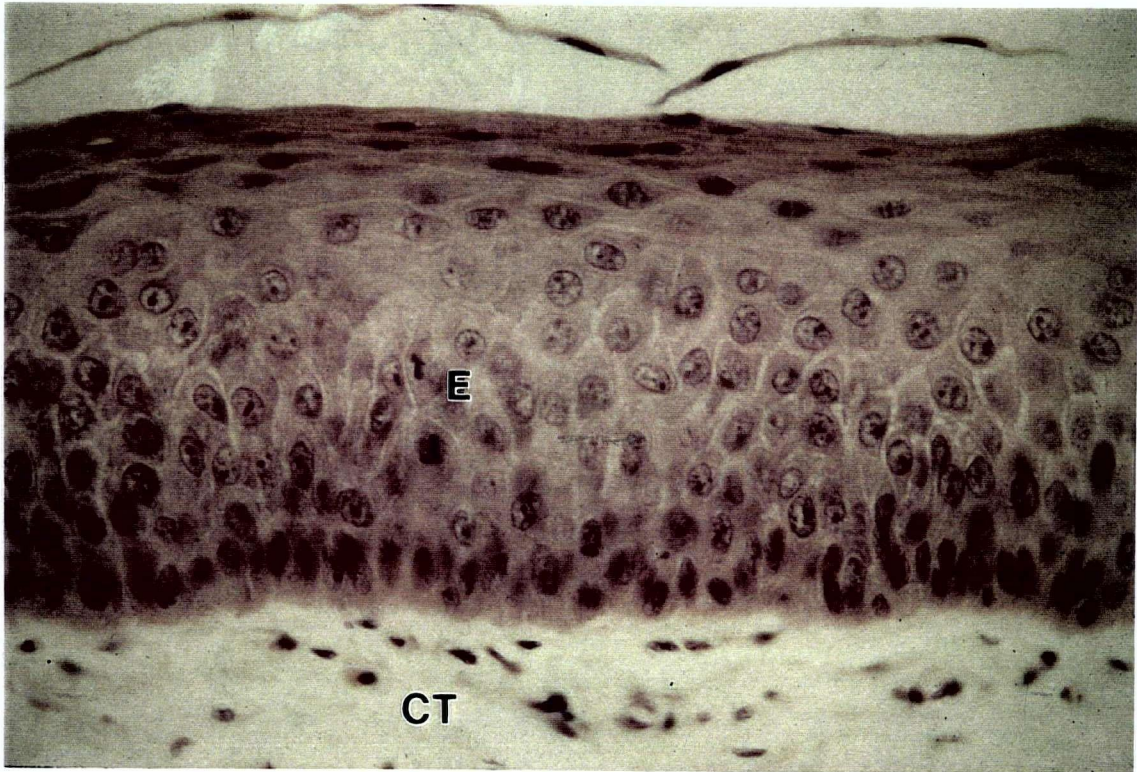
Non-keratinized oral epithelium; E=Epithelium, CT=Connective tissue
